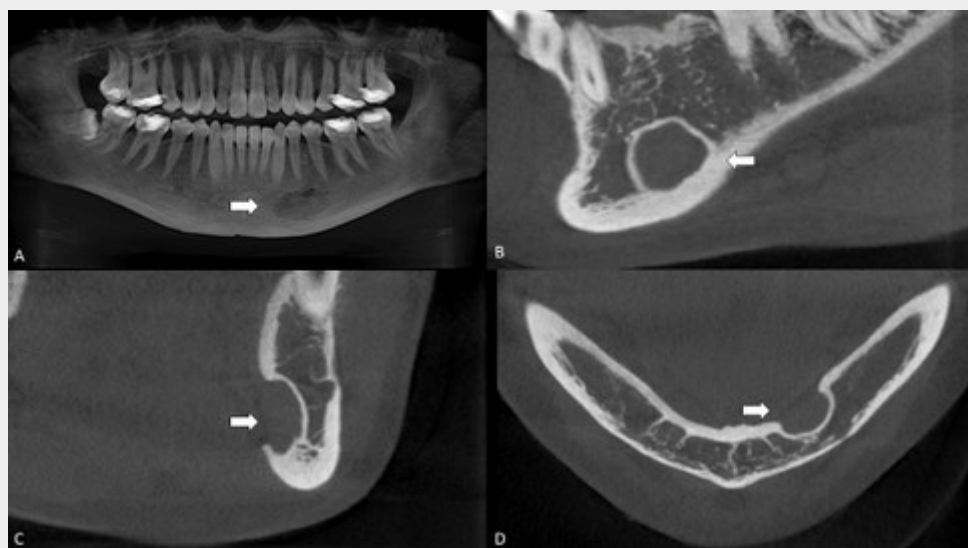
CBCT. A) panoramic reformation. B) sagittal, C) coronal and D) axial planes.
